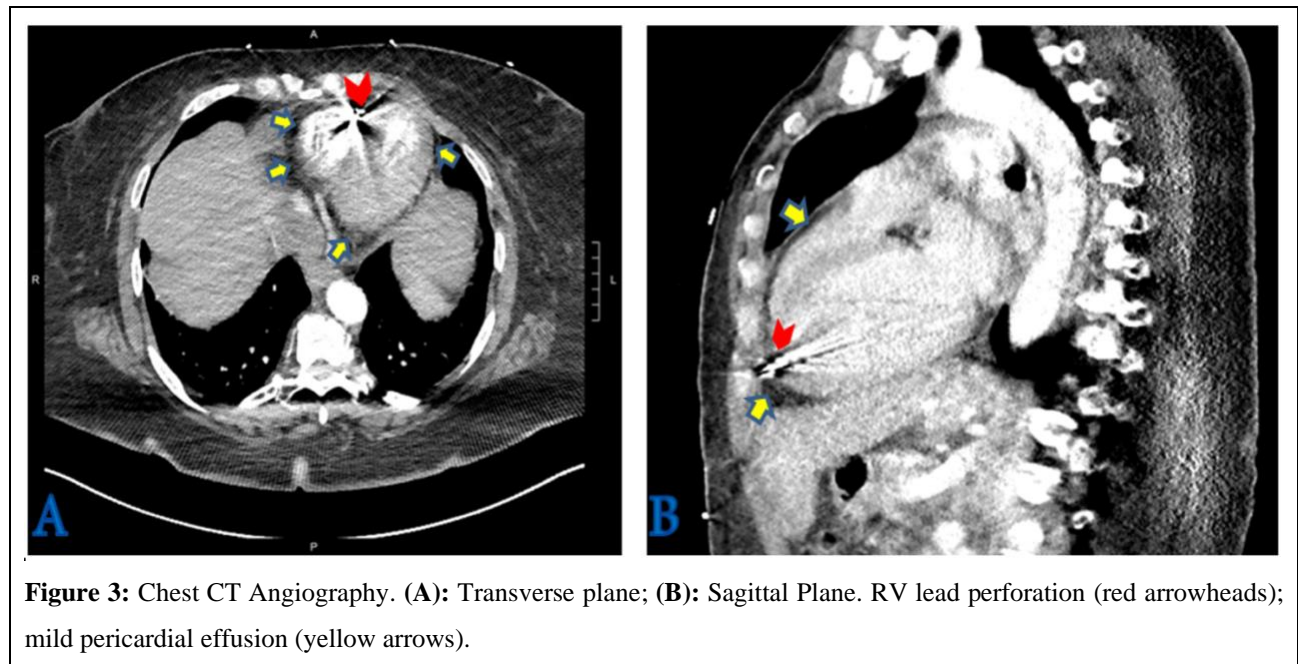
Chest CT Angiography. (A): Transverse plane; (B): Sagittal Plane. RV lead perforation (red arrowheads); mild pericardial effusion (yellow arrows).
